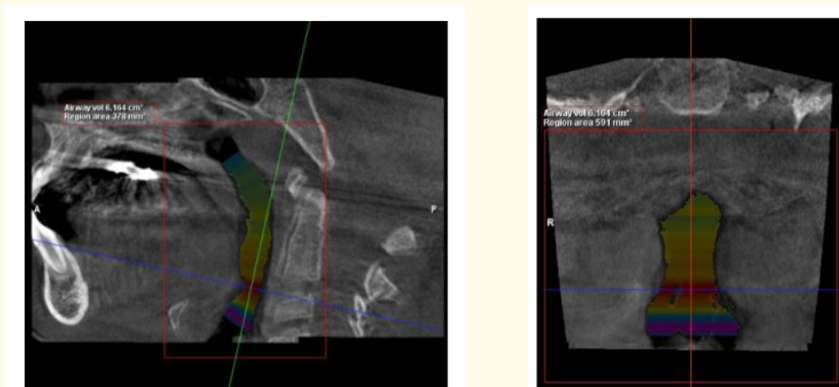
CBCT references and landmarks used for oropharyngeal airway - superior border (ANS-PNS plane), inferior border (A line passing through the tip of the epiglottis parallel to ANS-PNS plane).
